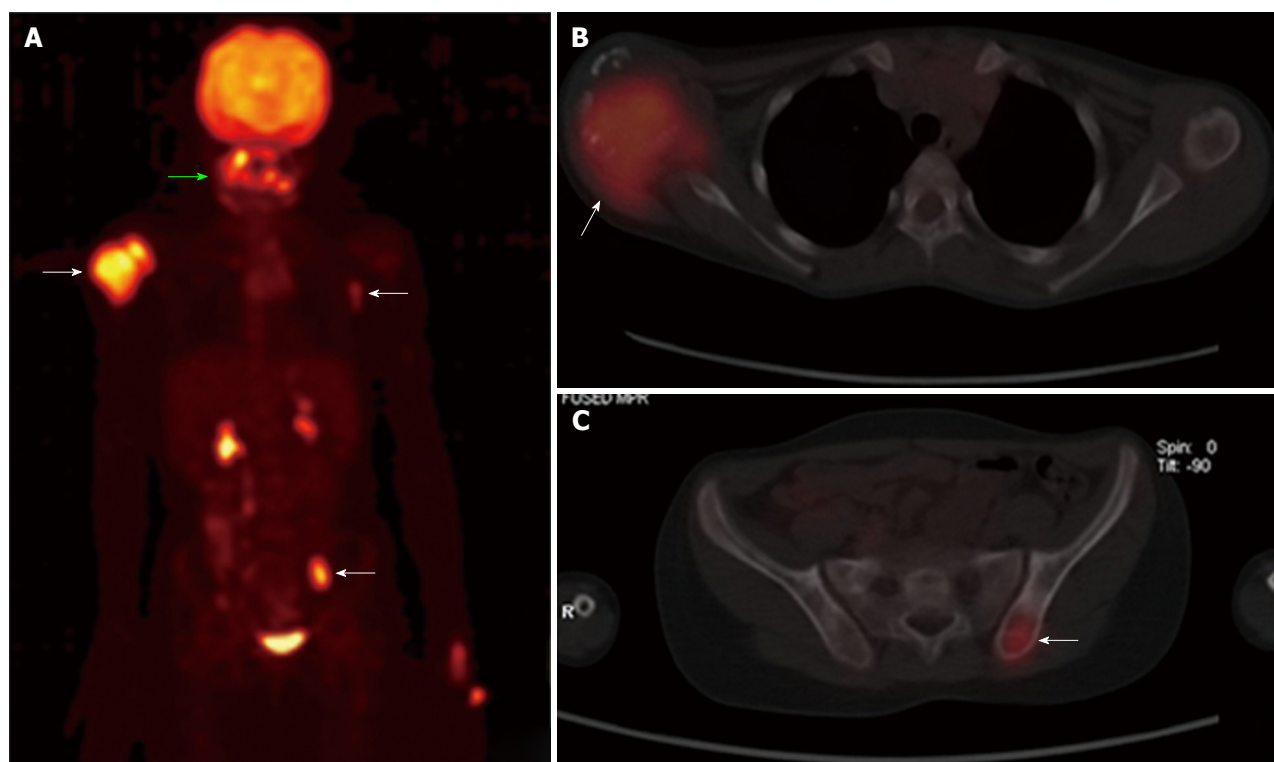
Positron emission tomography-computed tomography whole body maximum intensity projection image (A), axial fused images of chest (B) and pelvis (C) reveal areas of increased fluorodeoxyglucose uptake in right humeral head (arrow), the paranasal sinuses (green arrow), left thoracic wall (arrow) and left iliac bone (arrow). Note the physiological uptake and excretion in the kidneys and urinary bladder.
